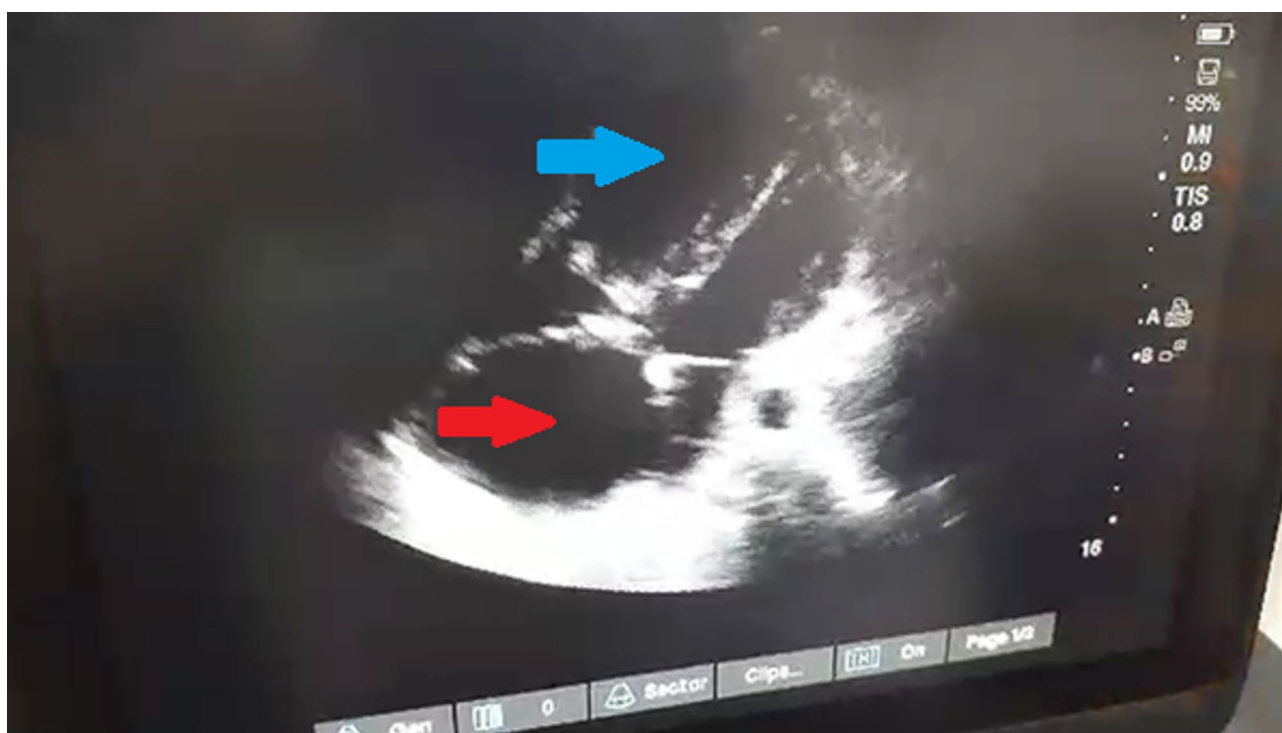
Transthoracic echocardiography imaging. Four chamber off-axis view at. Severe RV (blue arrow) and RA dilation (red arrow)
